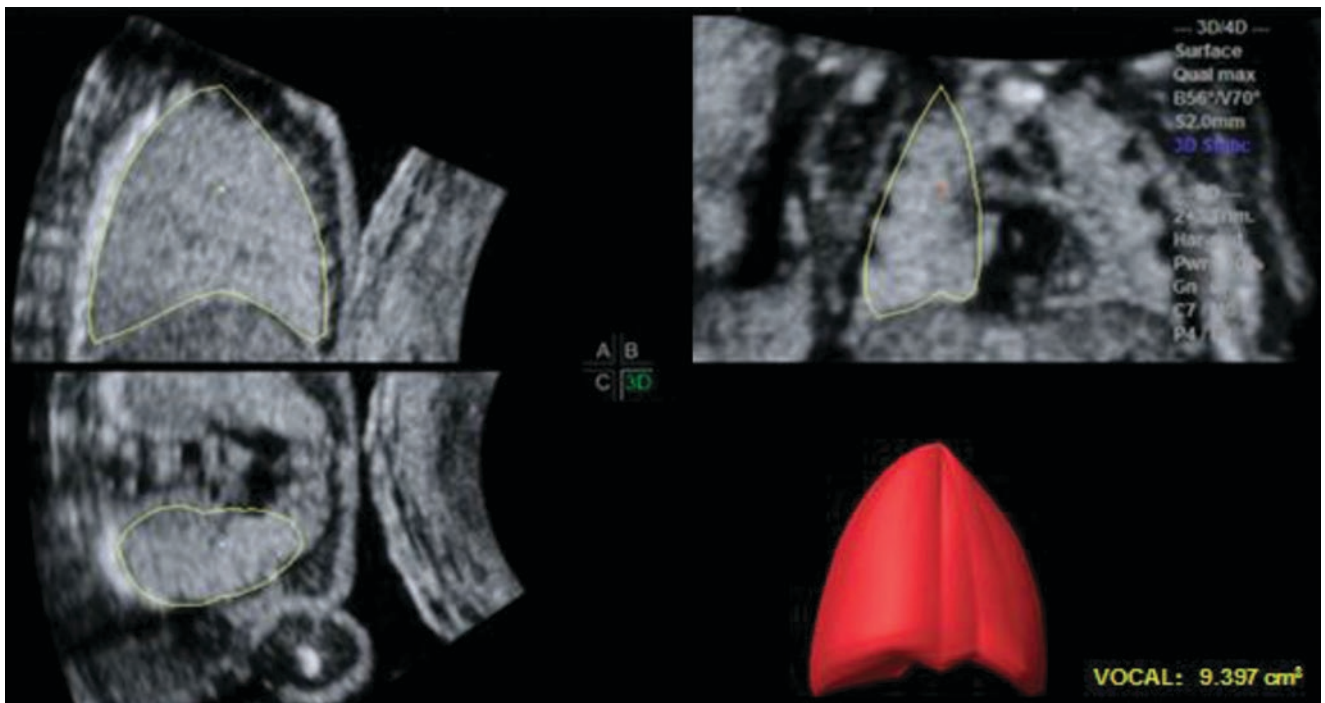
The measurement of lung volume by 3-D ultrasound
